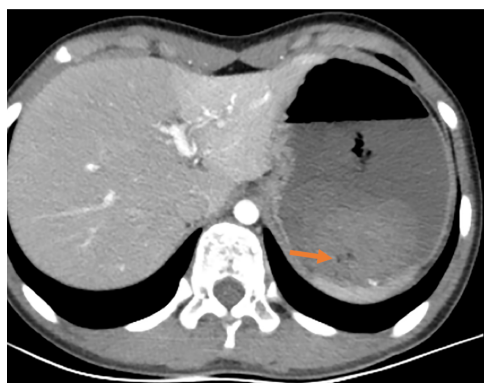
Abdominal enhanced computed tomography. It showed that the stomach was visibly dilated and filled with fluid, with blood clots visible. The arrow indicates the blood clot.
